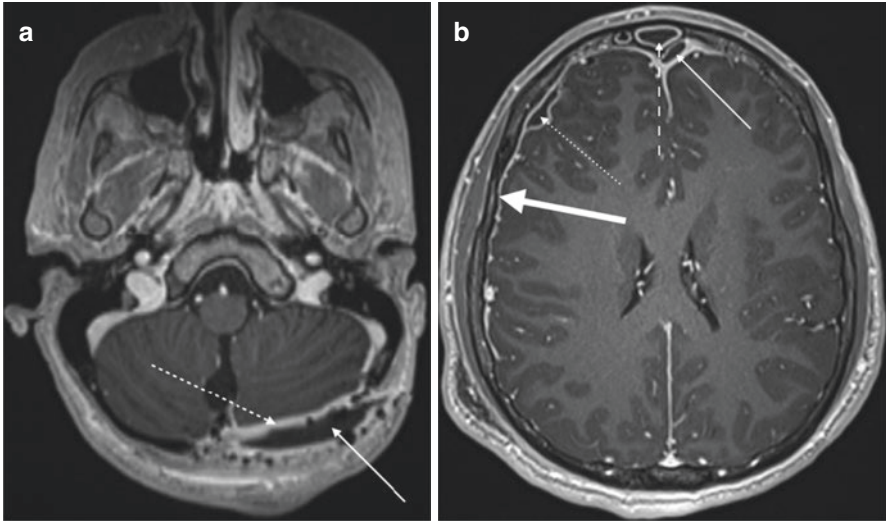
(a) Post Contrast MRI in a patient with a post craniotomy epidural abscess. T1 post contrast image in axial view showing hypointense collection (solid arrow) posterior to the cerebellum. The dura underlying the collection is avidly enhancing in response (broken arrow). (b) Post contrast MRI in a patient with both epidural and subdural infection. Note in this image of a T1 sequence MRI in axial view post contrast, the patient has evidence of both epidural abscess (solid skinny arrow) as well as a subdural empyema (broken arrow). The frontal sinus is avidly enhancing (dashed arrow) suggestive of a frontal sinusitis and possible nidus for infection. Also note the avid leptomeningeal enhancement on the more afflicted right side (broad solid arrow) in comparison to the left
